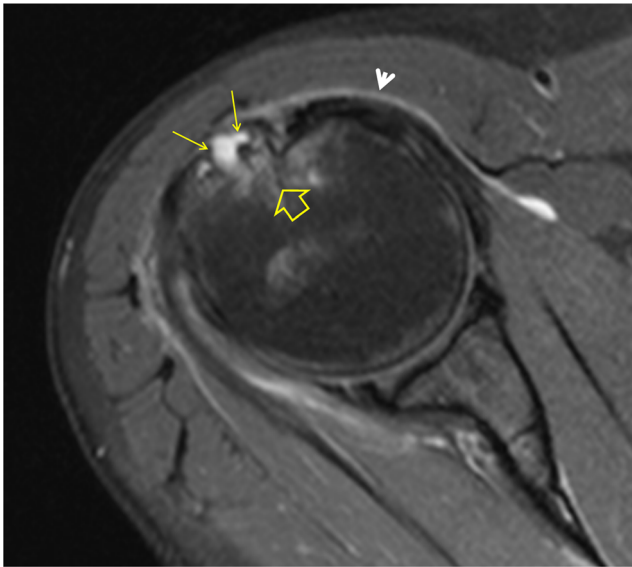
A 47-year-old female patient with a 7-month history of pain. The fat-suppressed axial PD-weighted MRI shows cortical irregularity and a subcortical cystic change (*arrows*), bone marrow oedema (*open arrow*) and subacromial bursitis (*arrowhead*)
